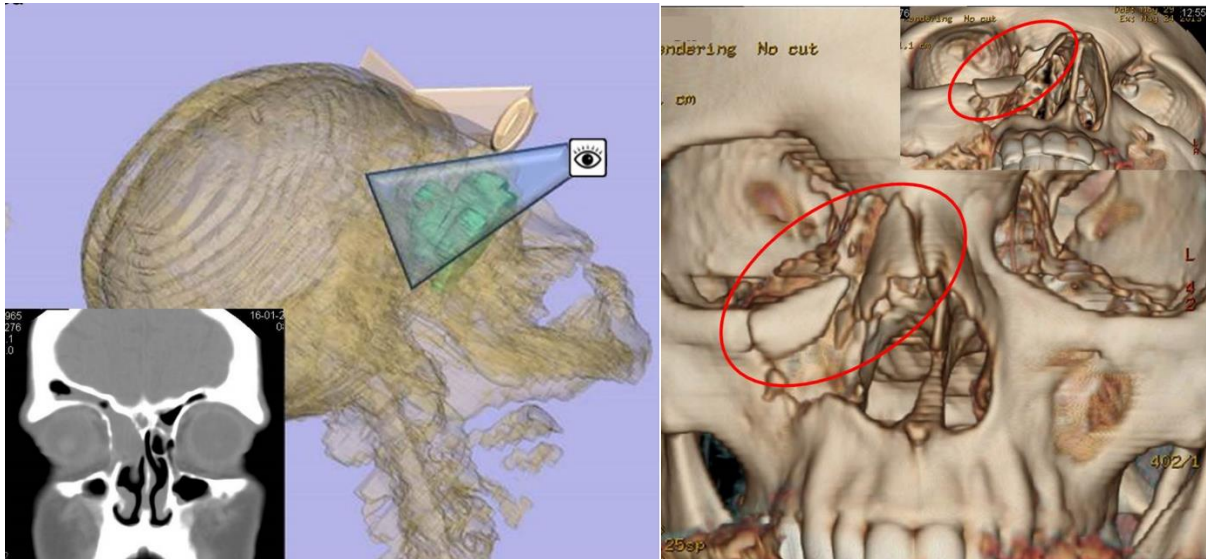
preoperative CT and 3D reconstruction (blue triangle shows the field of view during operation, the tumor mass is colored green), Figure 4b: postoperative 3D CT reconstruction with bone window, red oval line shows the repositioned osteoplastic flap.
